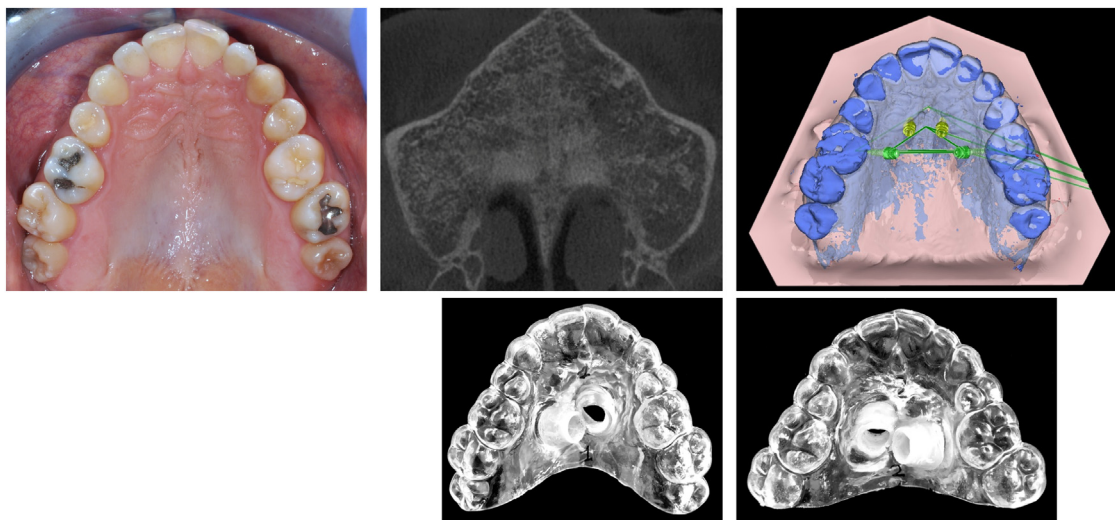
A female patient, 35 years old, presented with mild anterior crowding in the upper and lower arch and a narrow maxilla. A pre-treatment CBCT examination was conducted to plan the implant position and assess suture maturation staging. Digital planning was utilized to design the placement of four implants, which were used to support and anchor the bone borne expander. Subsequently, surgical guides were created and 3D printed for use during the procedure.
